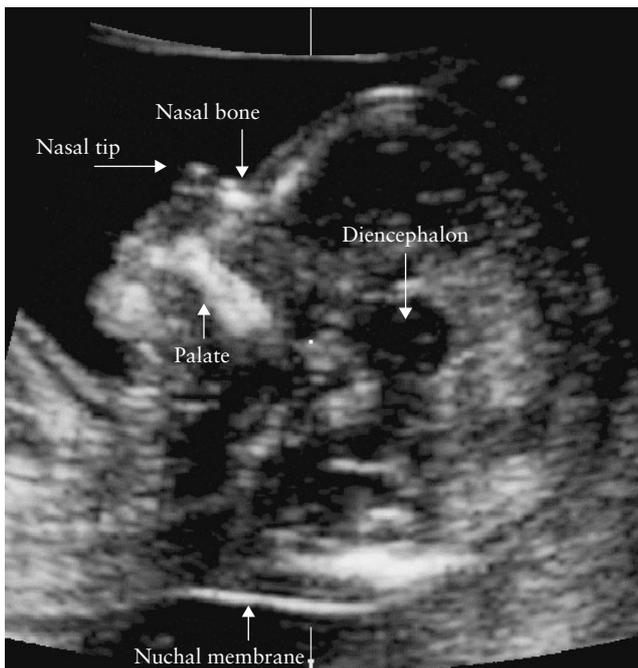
Ultrasound image of the fetal profile in the mid-sagittal plane demonstrating the tip of the nose and nasal bone, the rectangularly shaped palate, the translucent diencephalon and the nuchal membrane. This view is used for assessment of three markers of chromosomal defects at 11 + 0 to 13 + 6 weeks: nuchal translucency thickness, fronto-maxillary facial angle and nasal bone.
